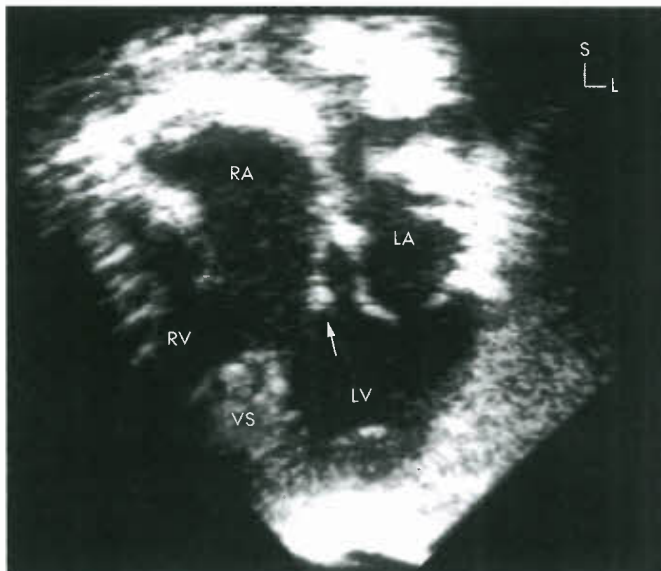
Atrioventricular override and straddling. Apical four-chamber view in a patient with isolated dextrocardia and severe (type C) straddling of the tricuspid valve in situs solitus, atrioventricular concordance, and dextrocardia. The arrow points to the septal tricuspid leaflet crossing into the left ventricle (LV) with a chordal attachment near the apex. The tricuspid annulus also overrides the ventricular septum (VS) and is partially committed to the LV. L, left; LA, left atrium; RA, right atrium; RV, right ventricle; S, superior.
